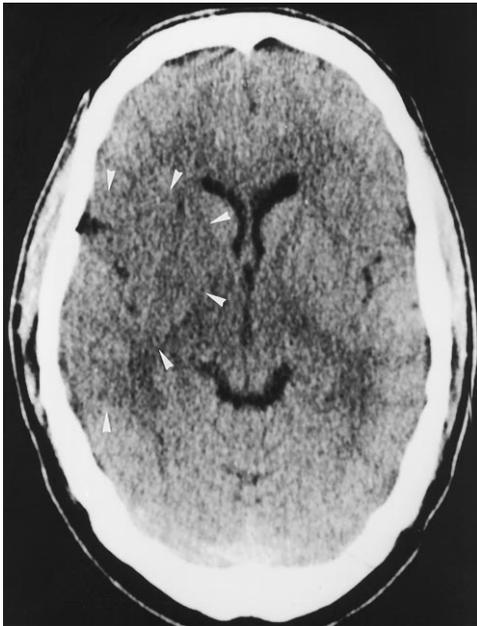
Twenty-year-old man with left-sided hemiparesis of 3 hours' duration. CT scan shows parenchymal hypodensity of the right insular cortex, putamen, pallidum, and temporal lobe with blurred margins (arrowheads). Interpretation by the reference neuroradiologist for all sections was as follows: "Parenchymal hypodensity of right lentiform nucleus and insular cortex covering 20% to 40% of the middle cerebral artery territory, slight tissue swelling with compression of right ventricle. No hyperdense middle cerebral artery sign."
